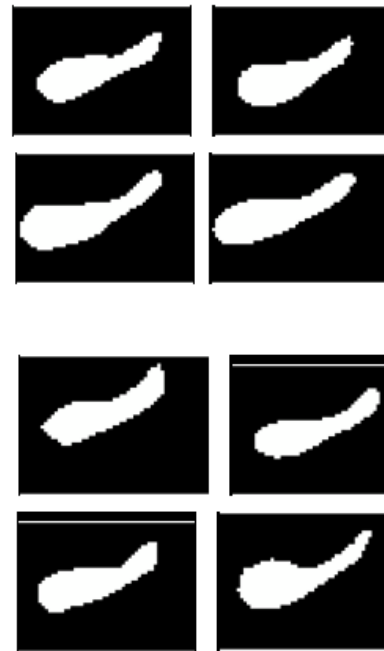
Binary images of the HC extracted from the NHP MRI
